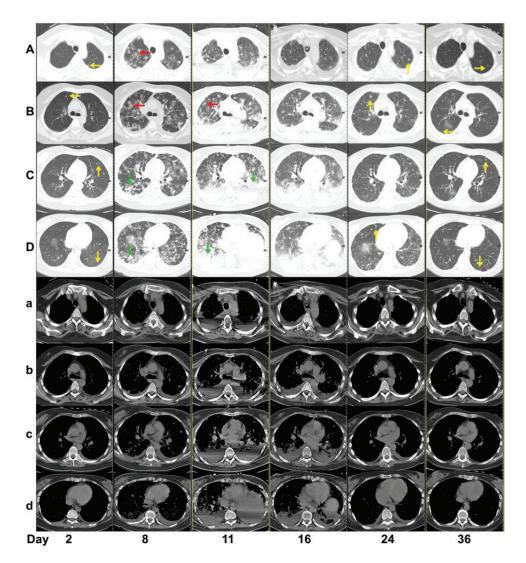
Dynamic evolution of chest computed tomography in a 30-year-old female that presented with nausea, abdominal pain and a skin rash that had spread over the body for 7 days. Lung window (rows A–D): initial imaging demonstrated multifocal nodular opacity with the slightly ground-glass opacity halo sign (yellow arrows) and bilateral pleural effusion (panel day 2). Lesions enlarged and developed to be ill-defined patchy areas (red arrows) and partly merged and formed consolidation (green arrows) (panel day 8, day 11). After effective treatment, ground-glass opacity and consolidation gradually dissolved (panel day 16, day 24) and a few nodular opacities similar to the initial lesions remained (panel day 36). Mediastinal window (rows a–d) showed some non-specific changes such as pleural effusion and compression atelectasis. The colour version of this figure is available at: http://imr.sagepub.com.
